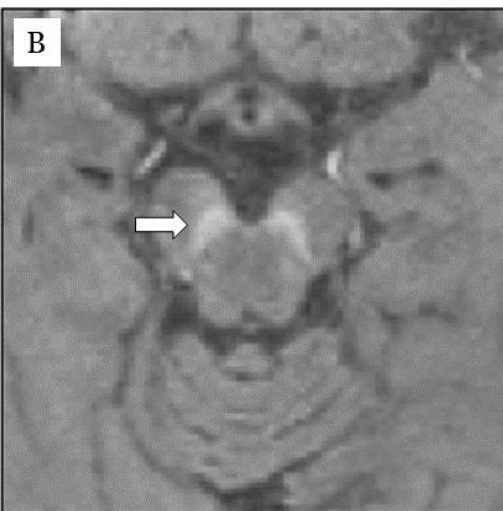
Example of neuromelanin-sensitive MRI.
